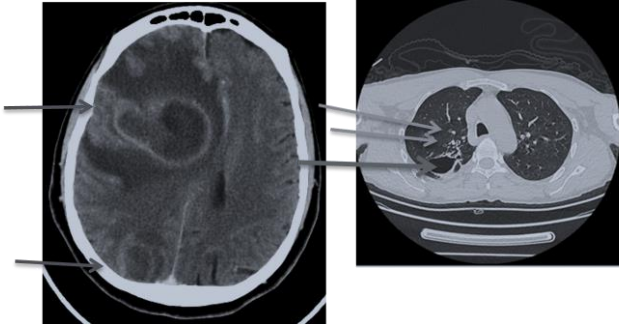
Cranial CT scan with contrast. Right frontal (54/51/47 mm) compressive on the lateral ventricle (subfalcorial herniation) and parietal abscess (32/26/22 mm) (Red arrows).
